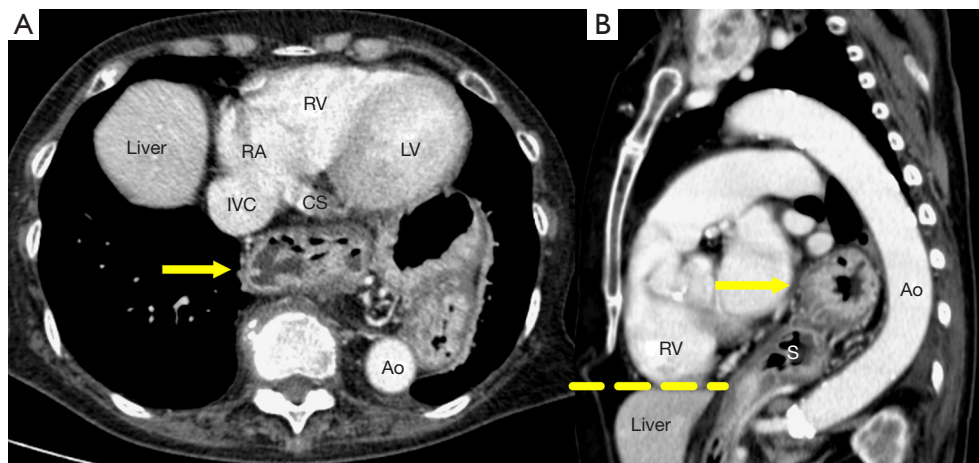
A patient's chest radiograph showed an abnormal retro-cardiac mass, which turned out to be a large hiatal hernia on CT imaging. (A) An axial CT imaging showing a retrocardiac mass containing air and fluid (arrow). (B) Sagittal CT imaging demonstrating the retrocardiac mass (arrow) was in continuation with the stomach (S) that lies below the diaphragm (yellow line), consistent with a hiatal hernia. CT, computed tomography; RA, right atrium; RV, right ventricle; LV, left ventricle; CS, coronary sinus; IVC, inferior vena cava; Ao, aorta; S, stomach. Courtesy of Dr. Thatchai Hantrakul.
